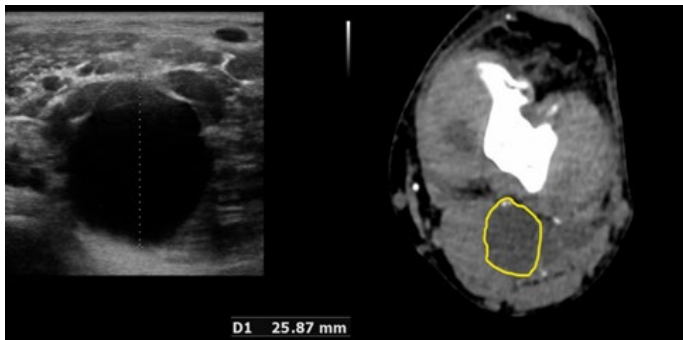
Ultrasound imaging showing a bilobed anechoic lesion compressing the left popliteal artery. Angio CT scan showing complete occlusion of the left popliteal artery and the cystic lesion in its place.
